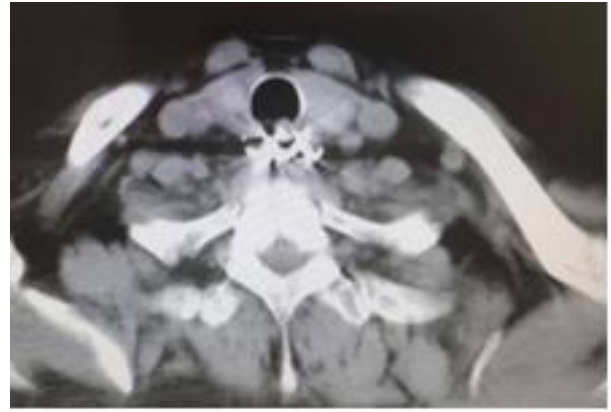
CT thorax of denture at upper esophagus.
